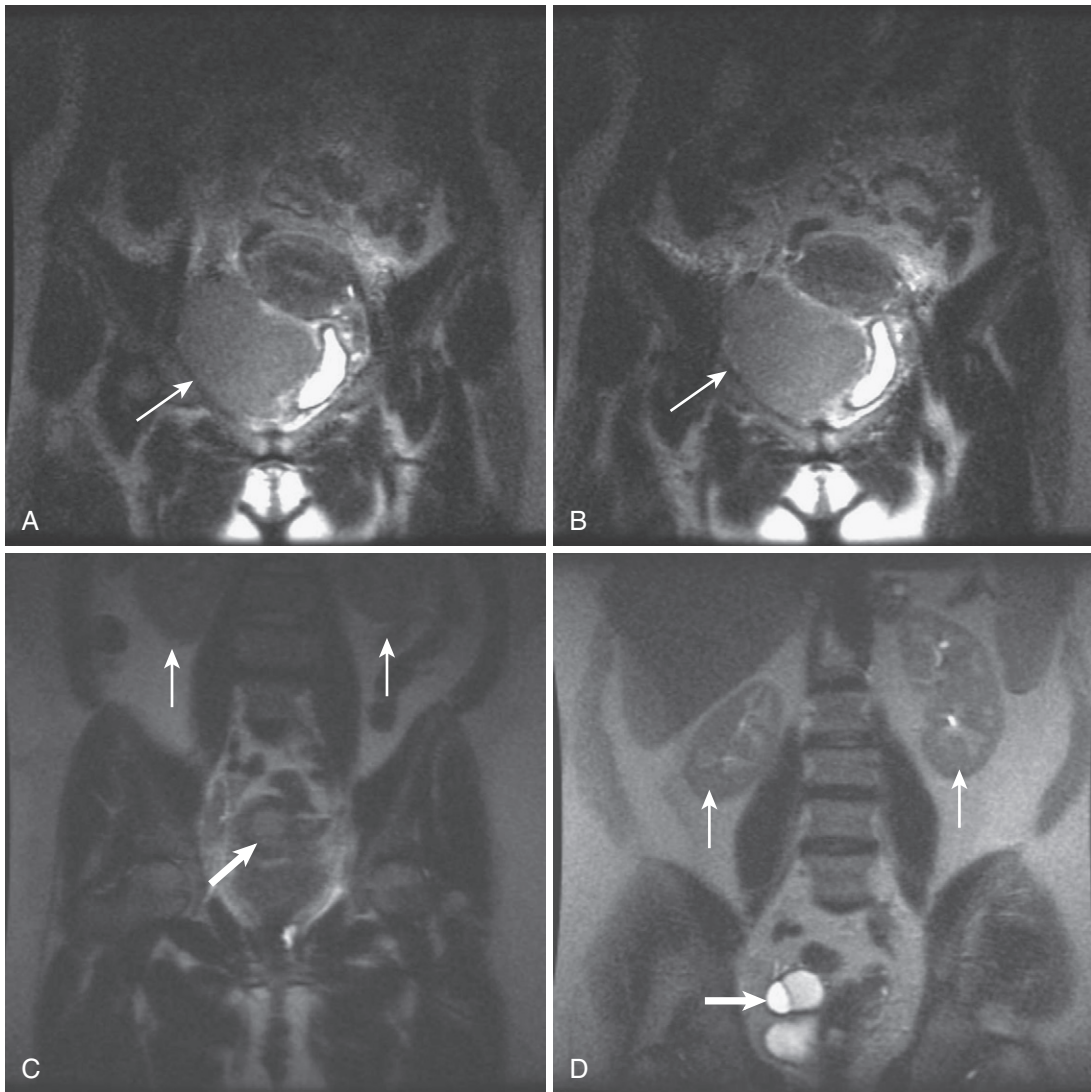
Poor coil placement. A and B, Coronal T2-weighted images of the pelvis show maximal signal centered at the level of the pubic symphysis rather than the region of interest—the uterus and adnexa—and remember that the kidneys should be visualized in all cases. Note the homogeneously hyperintense mass in the right hemipelvis in this patient with pelvic lymphoma (*arrow*). C, Coronal T2-weighted image in a different patient demonstrates maximal signal arising from the region of the uterus with visualization of the kidneys (*thin arrows*) in a patient with cervical carcinoma (*thick arrow*). D, The kidneys (*thin arrows*) are conspicuously well visualized on this coronal T2-weighted image with maximal signal emanating from the abdominopelvic junction in this patient with a right-sided cystadenofibroma (*thick arrow*).
